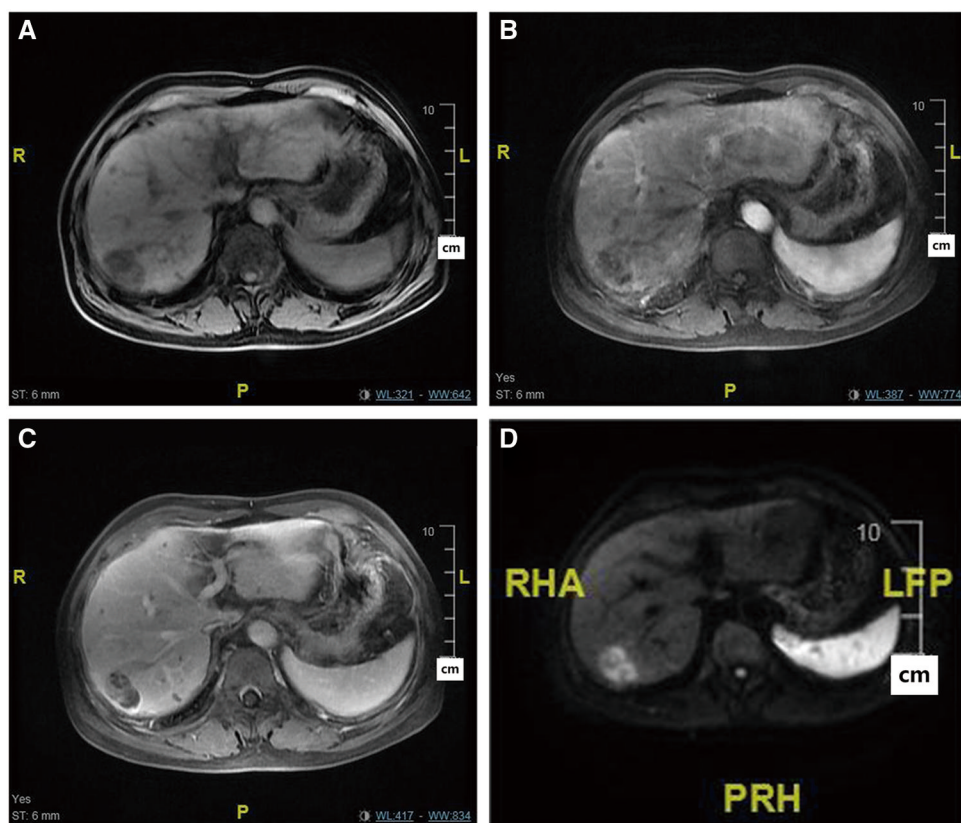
Combined hepatocellular cholangiocarcinoma in a 69-year-old man. (A) T1-weighted image shows a hypointense tumor. Contrast-enhanced (B) arterial phase image shows rim hyperenhancement without arterial peritumoral enhancement; (C) delayed image shows a non-washout (depressive) enhancement pattern with enhancing capsule. (D) Diffusion-weighted image shows peripheral hyperintensity and central hypointensity.
